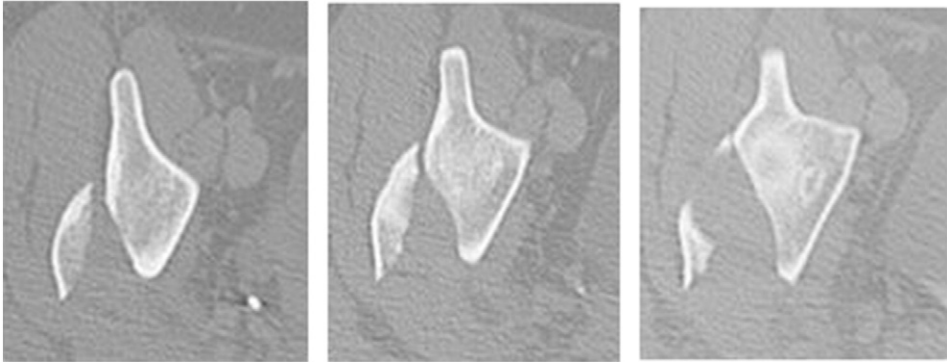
Preoperative axial CT.
